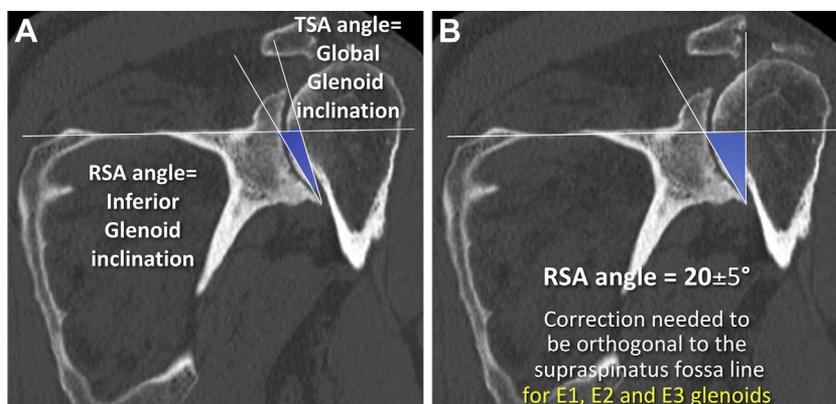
(A) Two-dimensional computed tomography scan cut showing the difference (about 10° on average) between the total shoulder arthroplasty (TSA) and reverse shoulder arthroplasty (RSA) angles. (B) The mean RSA angle, measured on 2- and 3-dimensional computed tomography scans, was 21° ± 5°, which represents the angle that needs to be corrected to place the baseplate orthogonal to the supraspinatus fossa line.
